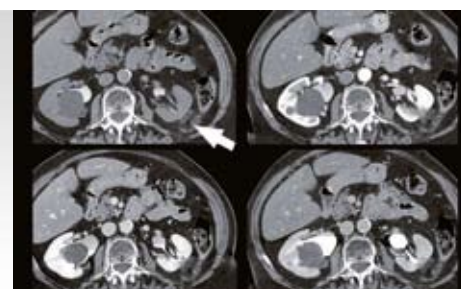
c: Contrast-enhanced CT at two years confirmed the success of the procedure.
